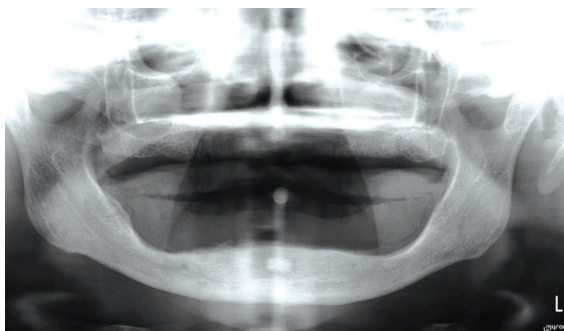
Panoramic radiograph and photos of the initial case. Patient comes to our observation with incongruous complete dentures.
